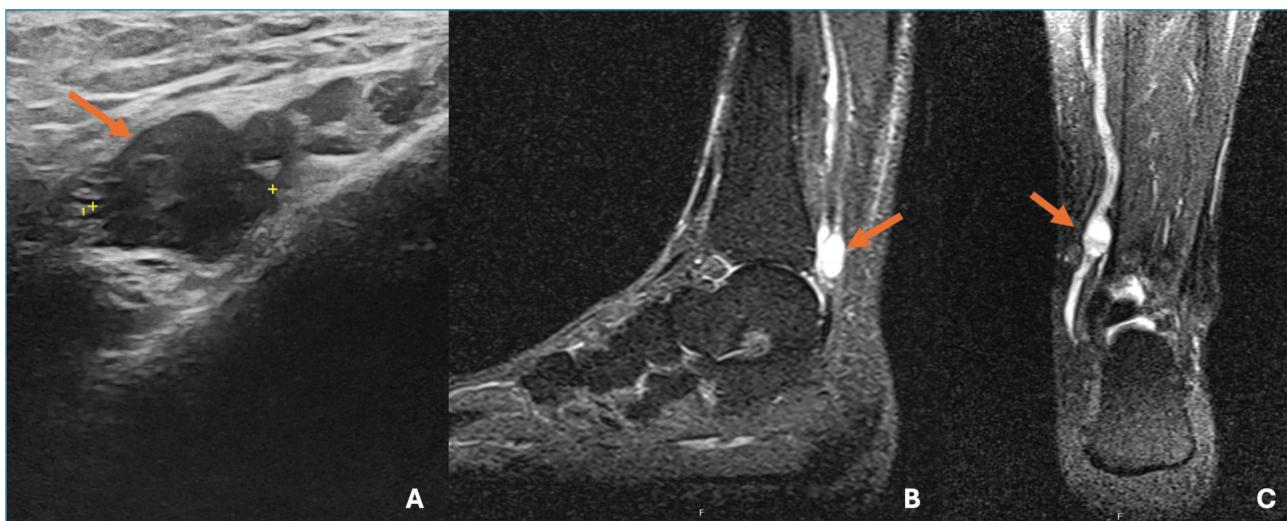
(A) Ultrasound of the posterior tibial nerve showing the nerve tumor as a hypoechoic mass within the nerve sheath (arrow); (B) Sagittal, turbo inversion recovery magnitude sequence magnetic resonance imaging of the ankle showing the nerve tumor as a hypointense structure posterior to medial malleolus (arrow); (C) Coronal, T2-weighted resonance imaging of the ankle with the nerve tumor (arrow).
